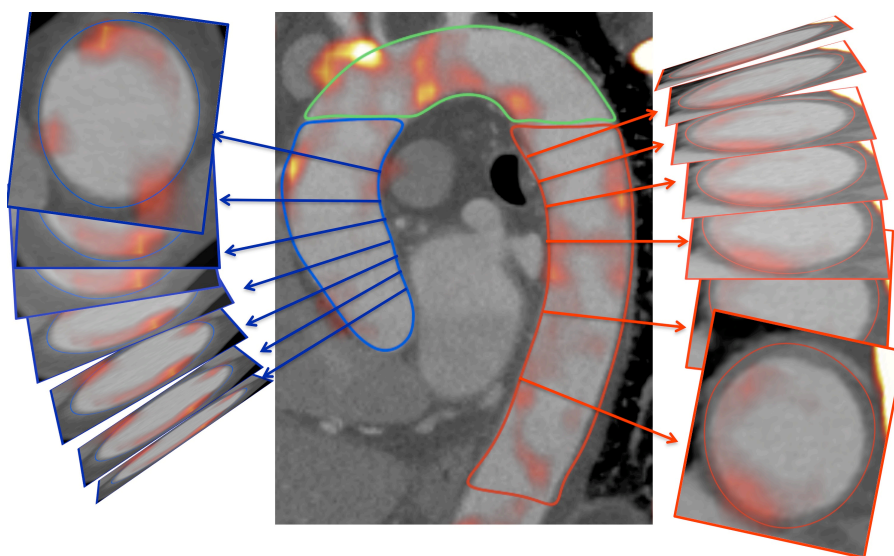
Fused PET-CT of atherosclerotic thoracic aorta. Uptake of ^{18}F -sodium fluoride in the wall of the ascending aorta, arch and descending aorta in patients with coronary artery disease.
